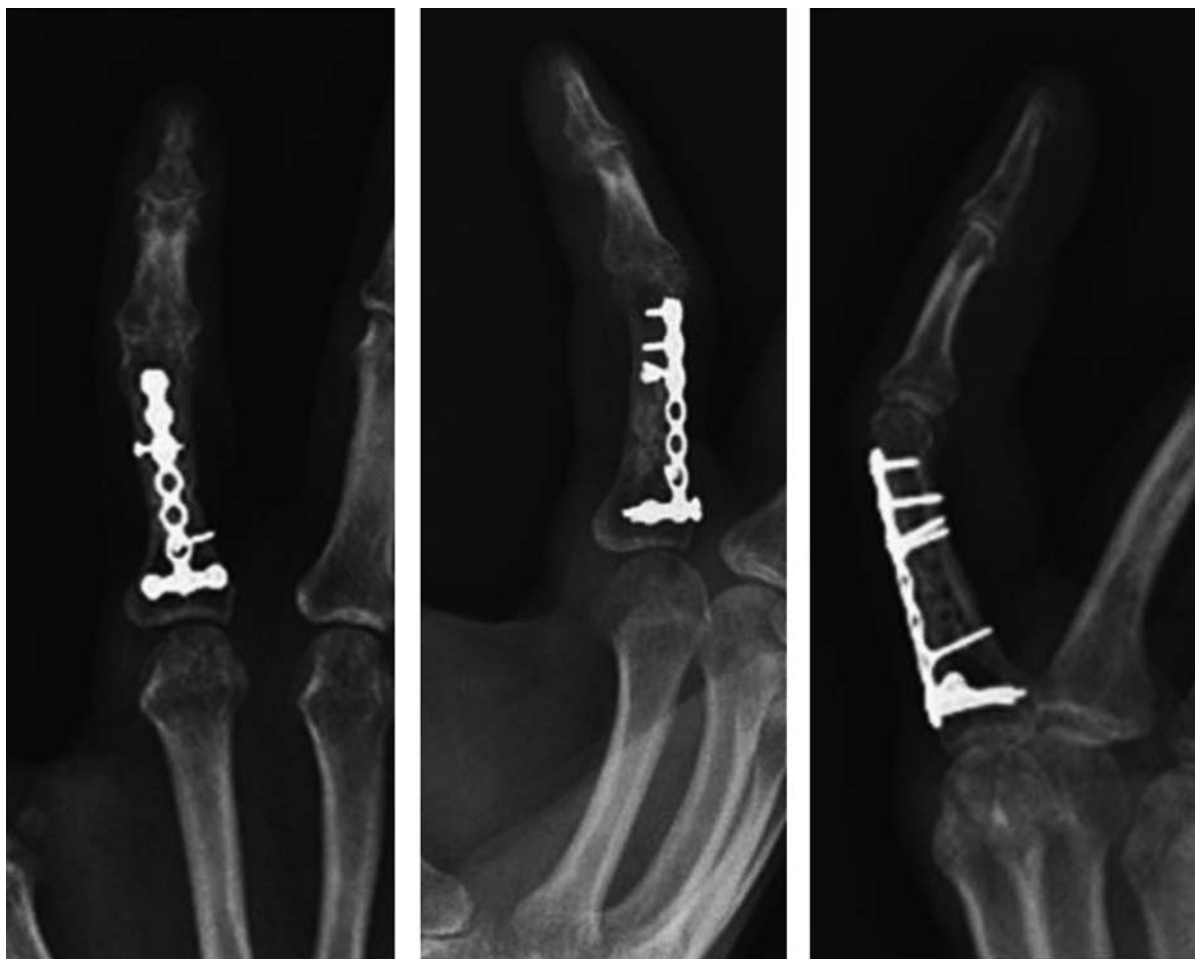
Postoperative radiographs after fixation with plate and lag screw construct.
